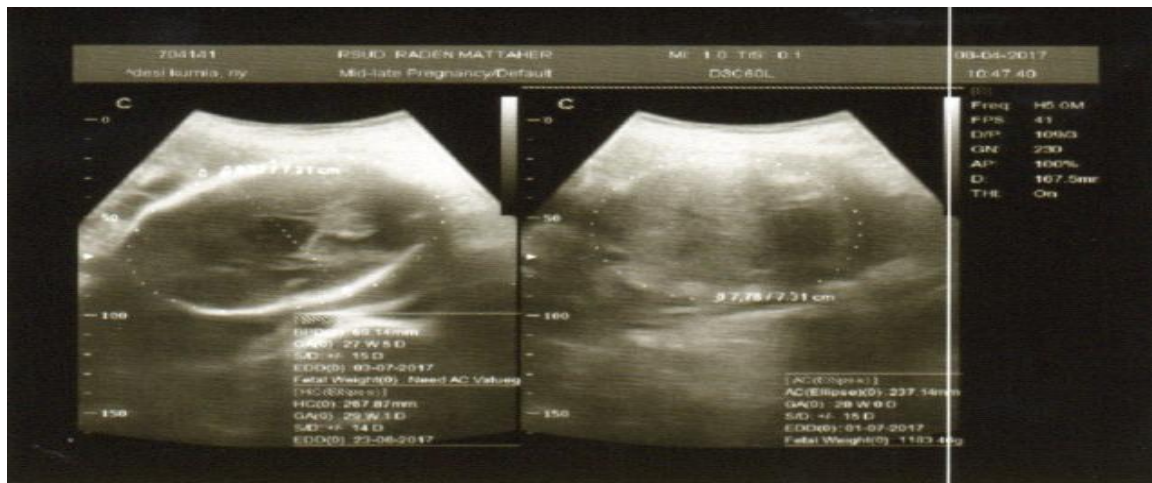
Ultrasound result
